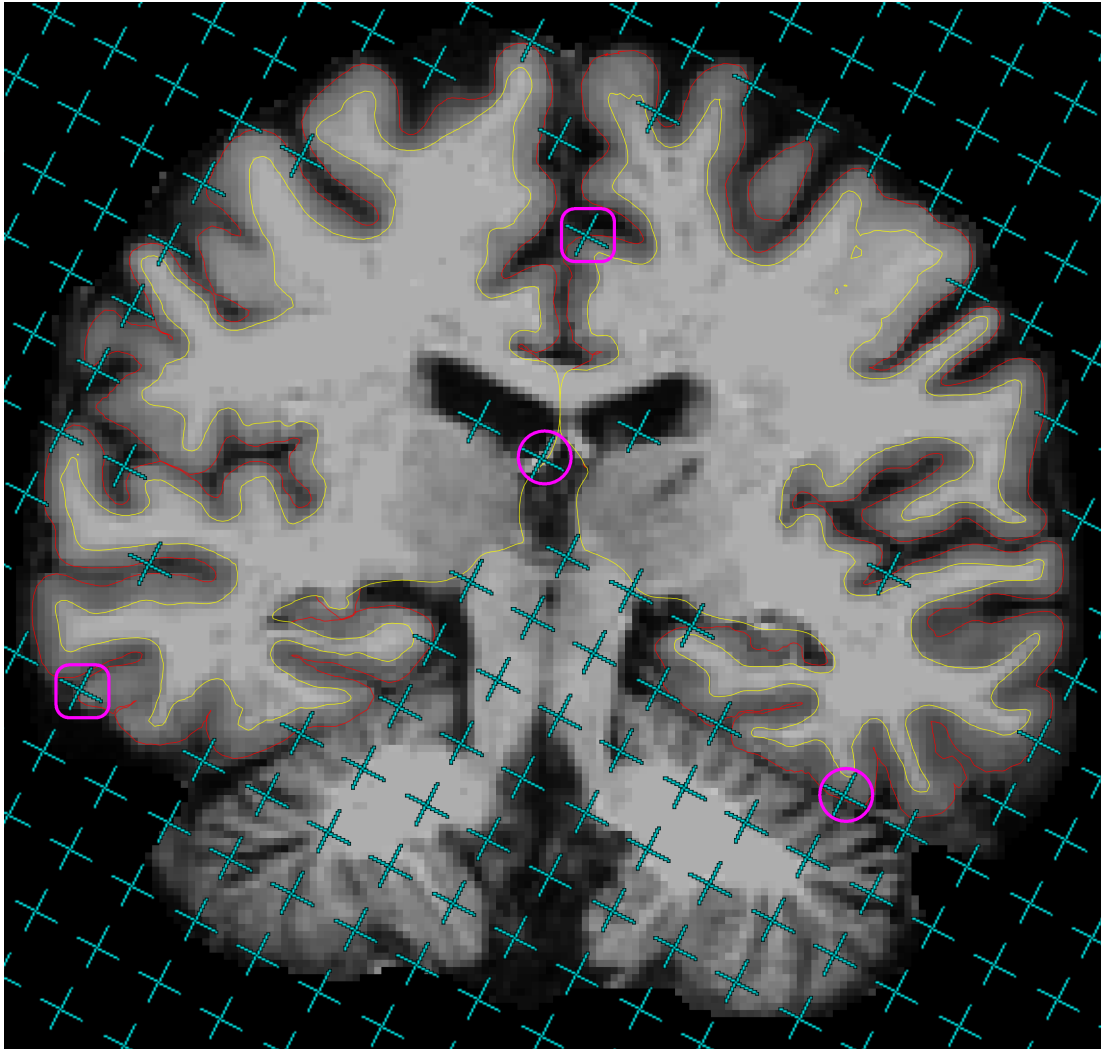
On the 8th slice of one brain MR image in the coronal view, uncounted test points (cyan) which miss the cerebral parenchyma or hit the ventricles are overlaid onto pial profiles (red lines) segmented by FREESURFER. Circles (pink) mark the uncounted test points which fall inside the grey matter boundaries (red lines) and rounded rectangles (pink, racetrack-like) mark the test points hitting exactly on the grey matter boundaries.
